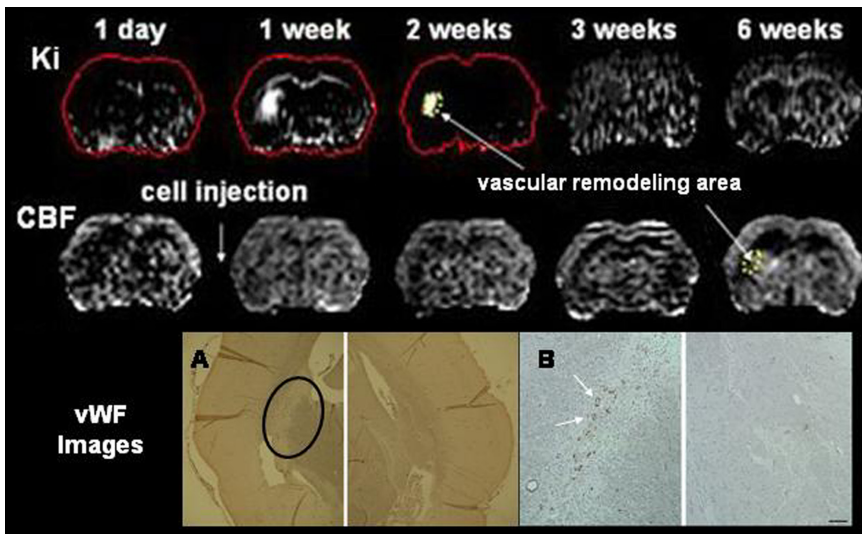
The evolution of changes in MRI K_i and CBF after restorative cell treatment.
